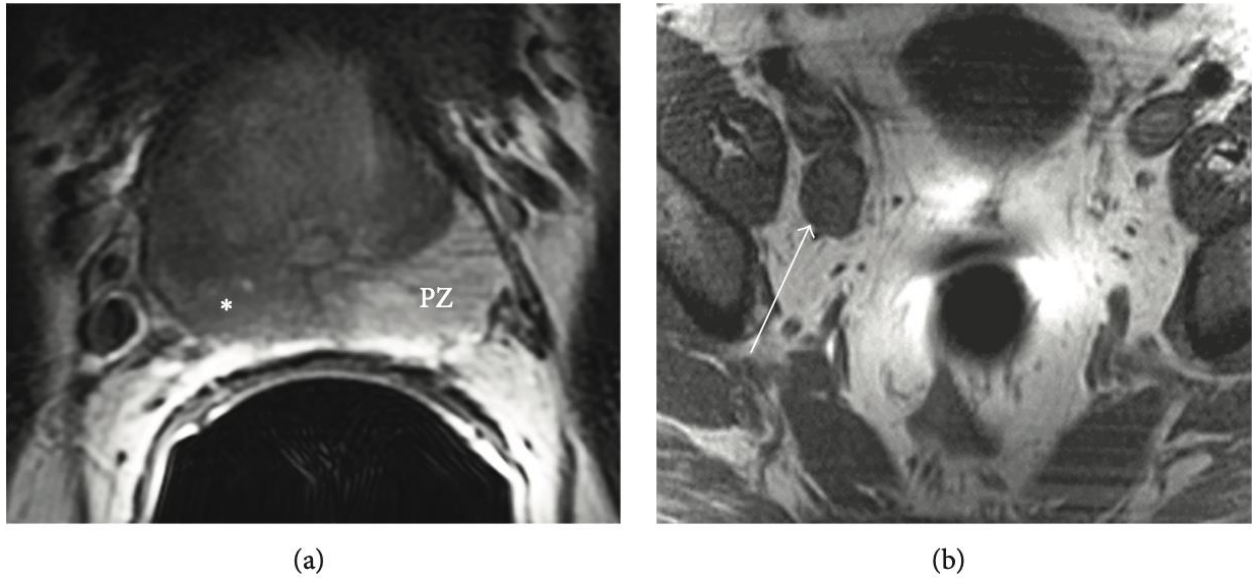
Two in a series of axial TW MRI images of the prostate gland with cancer. (a) showing hypointense signal within the right peripheral zone (*). The PZ is normal high signal-peripheral zone. (b) shows one in a series of axial T1W image with an enlarged right external iliac lymph node(29).
